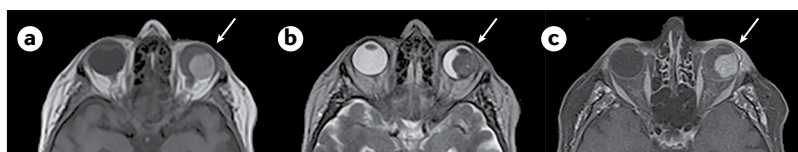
MRI of uveal melanoma. All images are from the same patient, with a large choroidal melanoma (arrows). T1-weighted (panel a), T2-weighted (panel b) and T1-weighted fat-suppressed (panel c) images with gadolinium enhancement are shown.
